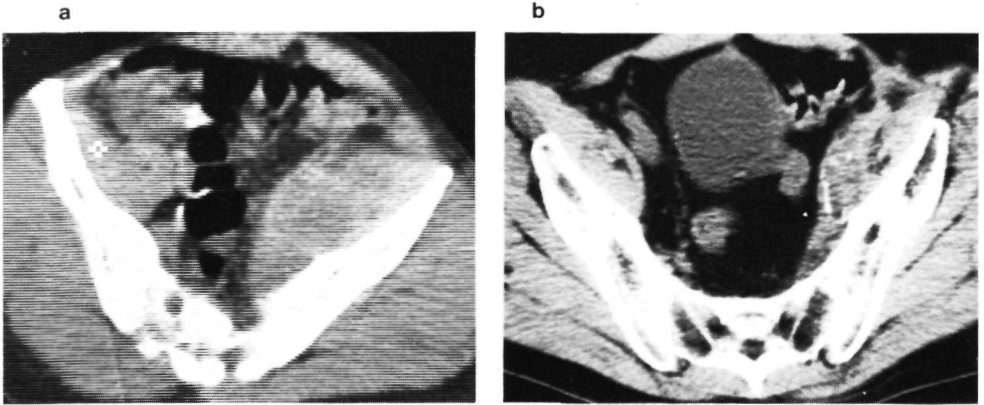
Case 9, non-Hodgkin's lymphoma. a) CT scan shows increased volume of iliopsoas compartment, thickening of gluteal muscles and subcutaneous edema on the left side. b) CT scan after treatment. Decrease of tumor volume. Soft tissue calcification in left parailiac region.
